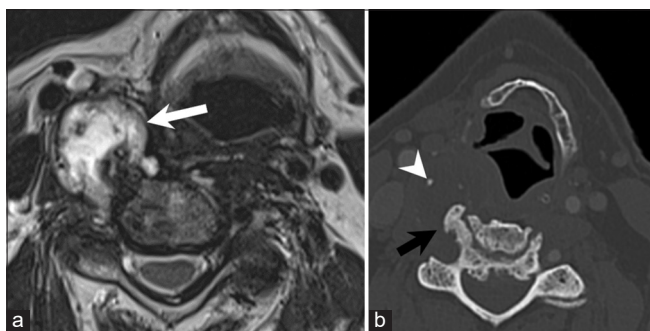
Osteochondroma with secondary chondrosarcoma. A 70-year-old man with secondary chondrosarcoma originating from the osteochondroma of the cervical spine presenting with palpable lump in the neck. Axial T2W MRI image (a) shows an exophytic T2 hyperintense mass arising from the right ventral aspect of C4 vertebral body (arrow). Axial CT image in bone window (b) shows a few small calcific foci within the tumor (arrowhead). Note a small underlying osteochondroma deep to the tumor (black arrow).
